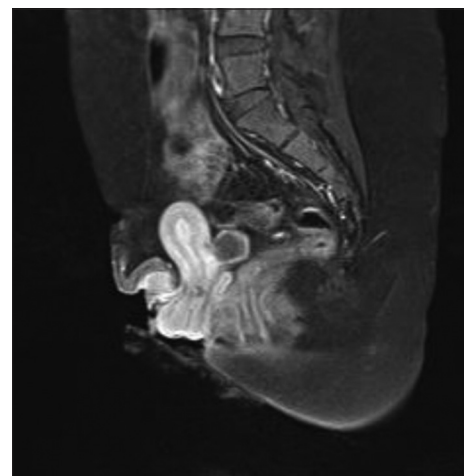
MRI imaging (sagittal reconstruction). The lack of the abdominal wall and the grade of exposition of the organs can be observed. MRI: Magnetic resonance imaging
